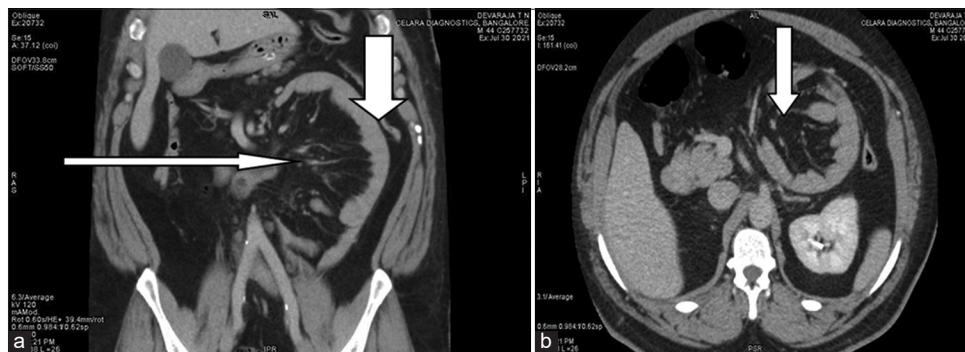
(a and b) Contrast-enhanced computed tomography images of abdomen showing bowel loops herniating through a defect in left paraduodenal region in left hyochondrium upto left lumbar region (arrow marks). Crowding of small bowel loops within the sac
